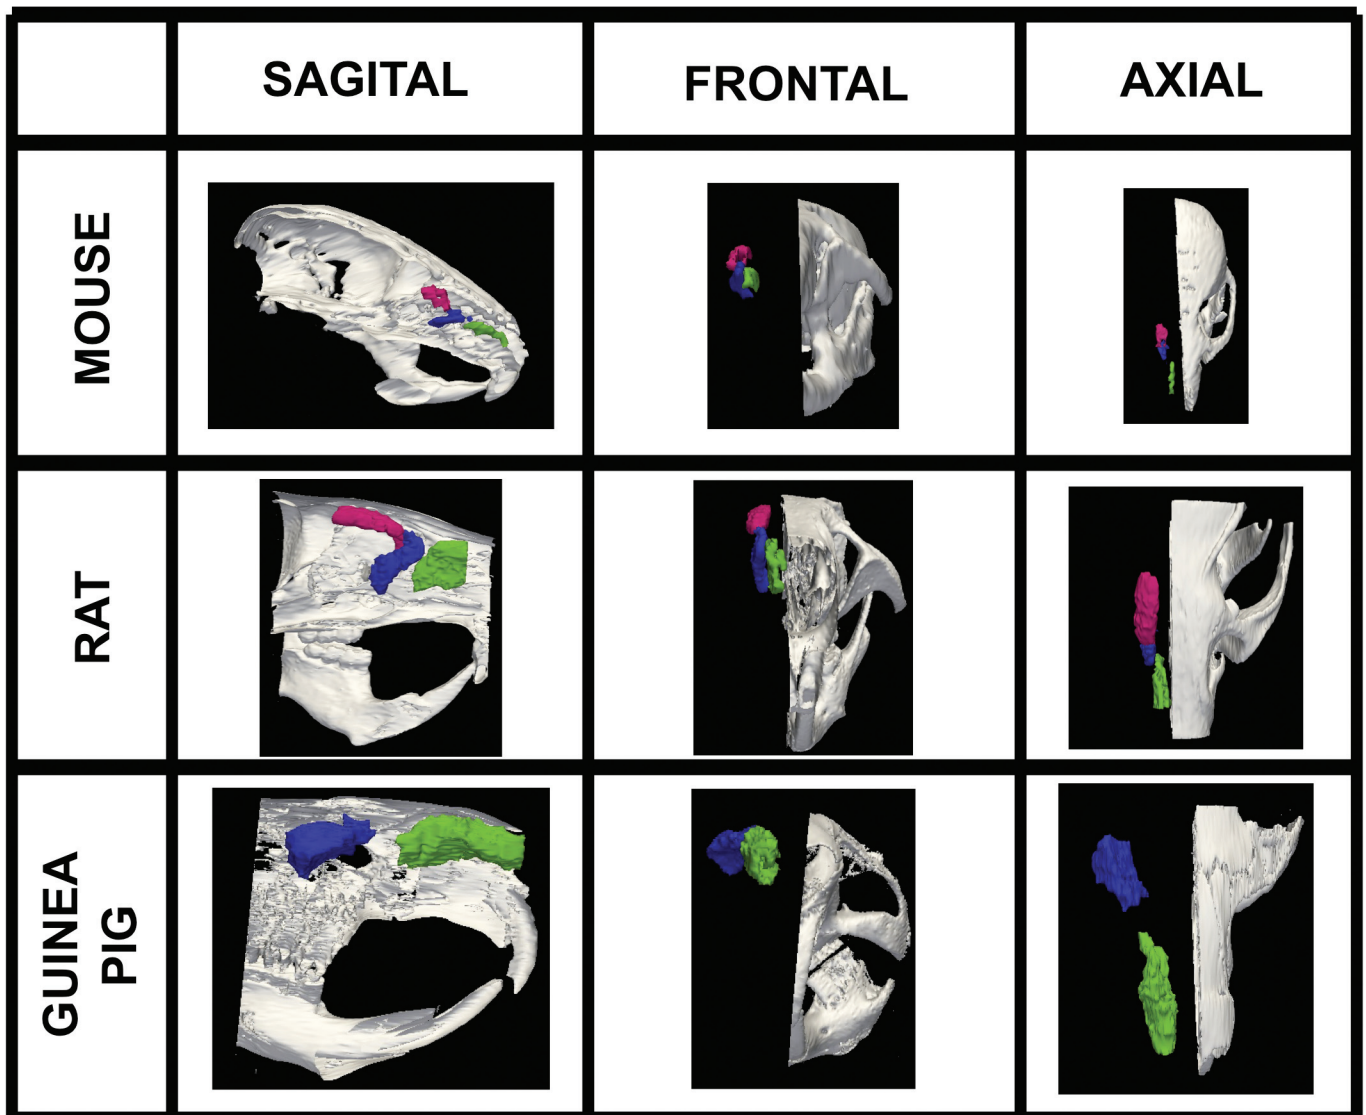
Volumetric surface renderings of paranasal sinus created from sequential computed tomography (CT) images. Three different orientations of the paranasal sinuses (anterior maxillary in green, posterior maxillary in blue, and anterior ethmoid in red) are shown with respect to location in skull according to species, all at different magnifications.
